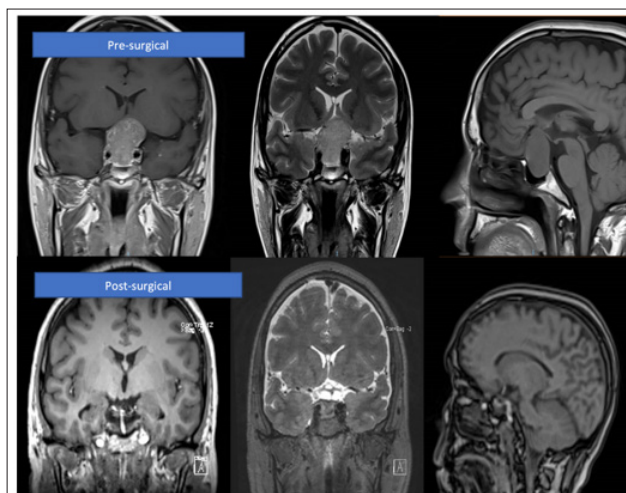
Representative MRI of Patient Case 2 with TSHoma
